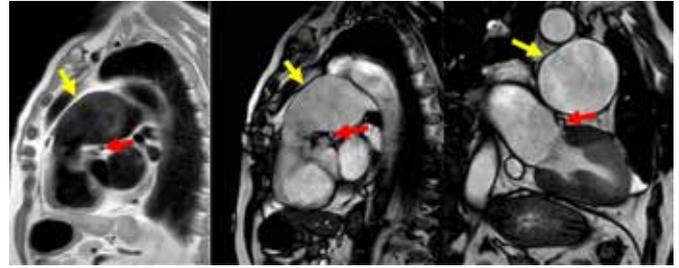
MRI showing pulmonary artery aneurysm (yellow arrow) revealing proximity to the left coronary artery (red arrow).
